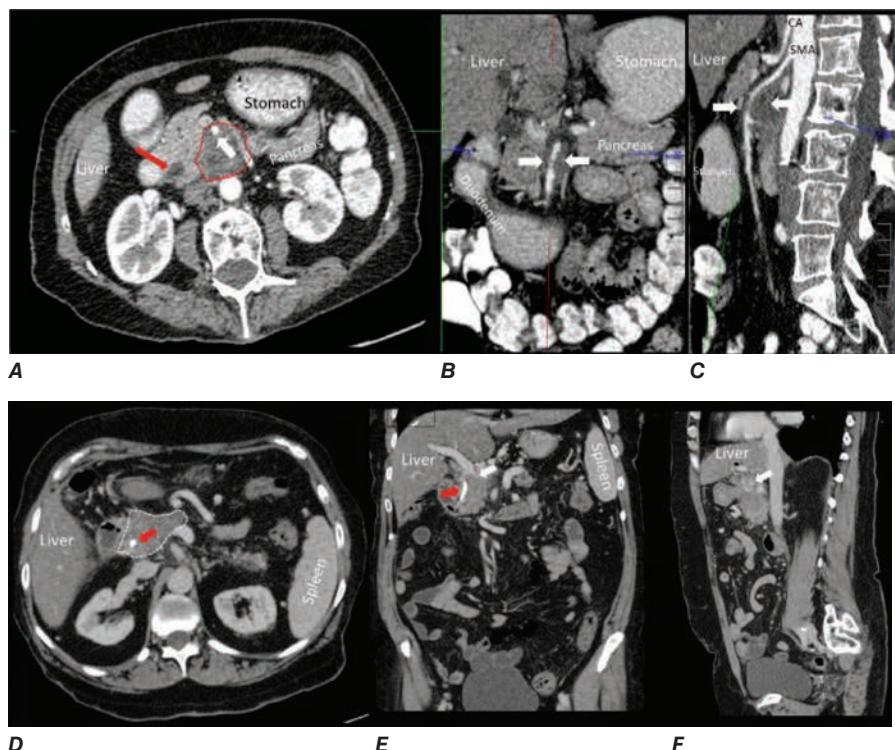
Selected images from contrast-enhanced CT in patients with locally advanced adenocarcinoma of the pancreas. A high-quality contrast-enhanced CT scan (arterial phase in panels A–C and portal venous phase in panels D–F) is required for optimal staging of pancreas cancer. Panel A demonstrates the typical features of adenocarcinoma of the pancreas on arterial phase axial CT scans (dotted outline) with tumor encasement of the superior mesenteric artery (white arrow). Note the dilatation of the common bile duct (red arrow). Panels B (magnified coronal) and C (sagittal) show reconstruction of CT images into additional orthogonal planes with exquisite details to confirm the unresectable nature of the tumor due to vascular encasement. Panel D demonstrates the typical features of adenocarcinoma of the pancreas on portal venous phase axial CT scans in a different subject. The dotted line outlines a pancreas cancer lesion in the pancreatic head, which is encasing the portal splenic confluence (dotted outline). Panels E (white arrow) and F show the pinched appearance of the portal splenic confluence by tumor abutment and invasion of the superior mesenteric vein (white arrow) on coronal and sagittal views. Note the presence of a stent in the common bile duct (red arrow) to help relieve biliary obstruction caused by the tumor. CA, celiac axis; SMA, superior mesenteric artery.
